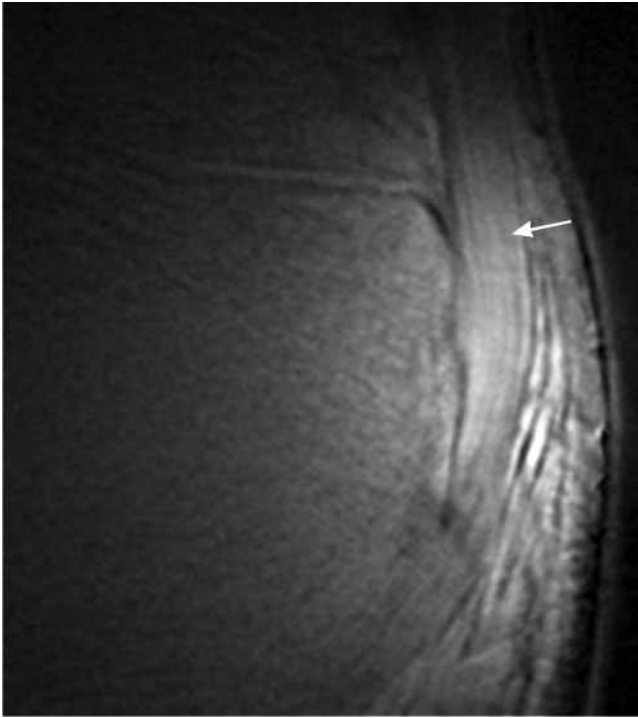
Ultrashort echo time MRI. Ultrashort echo time subtraction image (ultrashort echo time–gradient echo) showing the fibrillar structure of the Achilles tendon near the enthesis (arrow).
